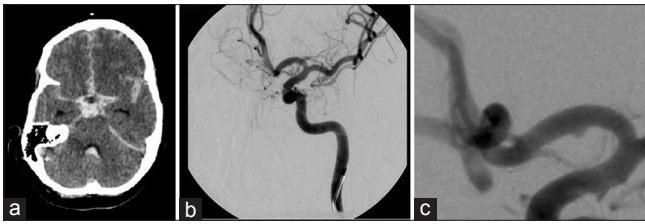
(a) Presenting computed tomography head demonstrating diffuse subarachnoid hemorrhage eccentric to the left with hydrocephalus. (b) Preoperative anteroposterior angiogram demonstrating seemingly normal vasculature. (c) Magnified left anterior oblique view angiogram demonstrating small mid A1 blister aneurysm
